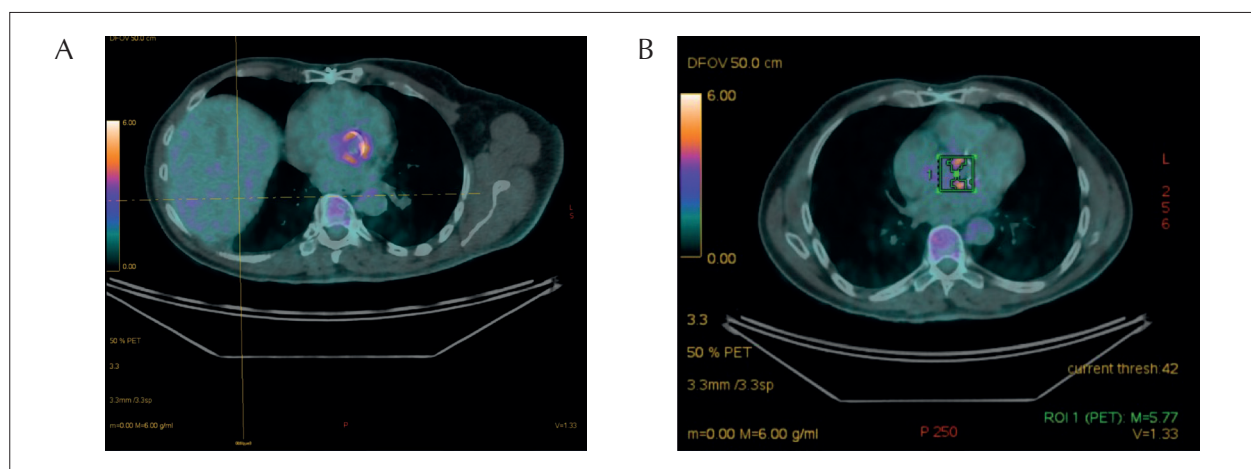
Male patient, 68 years old, with biological aortic prosthesis and history of fever and sweating, and normal transesophageal echocardiogram. (A) PET/CT with F18-FDG demonstrated perivalvar uptake of the radiopharmaceutical drug (B) Quantitative analysis demonstrated SUV of 5.77.
